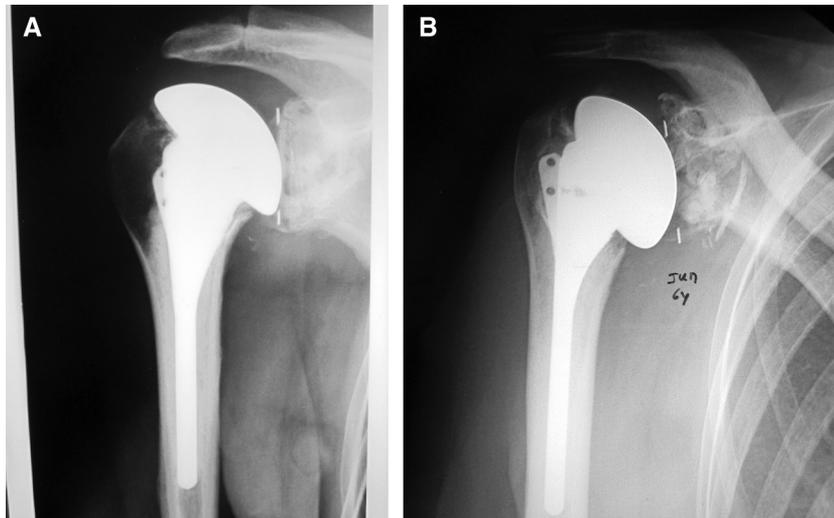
Anteroposterior radiographs of a poorly positioned humeral component. (A) On the radiograph obtained immediately postoperatively, the humeral component appears to be incompletely seated and overhangs the metaphysis inferiorly. (B) At 67 months postoperatively, there is definite radiographic loosening of the glenoid. This patient required revision and had an adjusted Constant score of 27 at final follow-up of 90 months.
